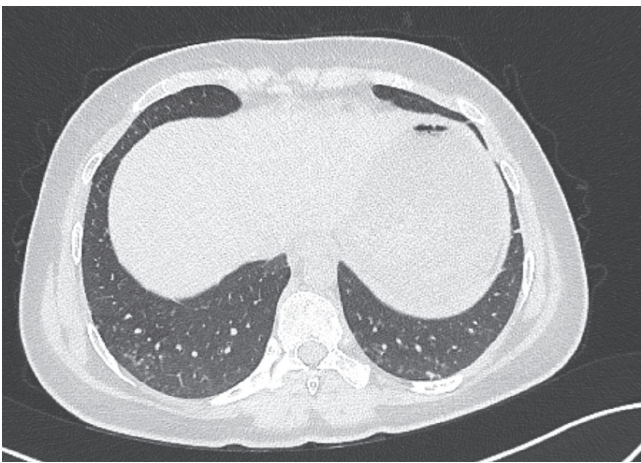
Follow-up thorax computed tomography showed marked improvement of the previous signs of consolidation.
